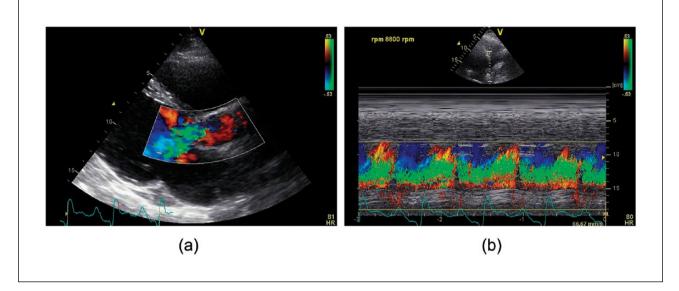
(a) Severe aortic regurgitation in left parasternal long axis transection. (b) Continous aortic regurgitation in systole and diastole in M-mode.
